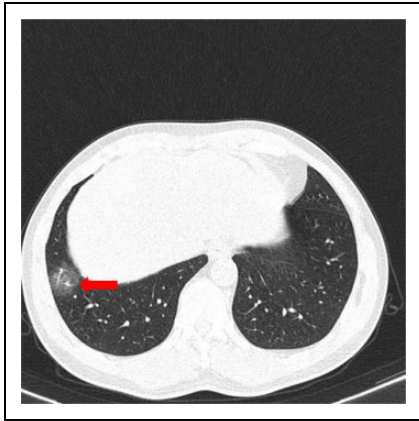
A 52-year-old male: Computed tomography scan revealed patchy pure ground-glass opacities (red arrow) at the lateral basal segment of the right lower lobe and vascular dilation inside the lesion.
